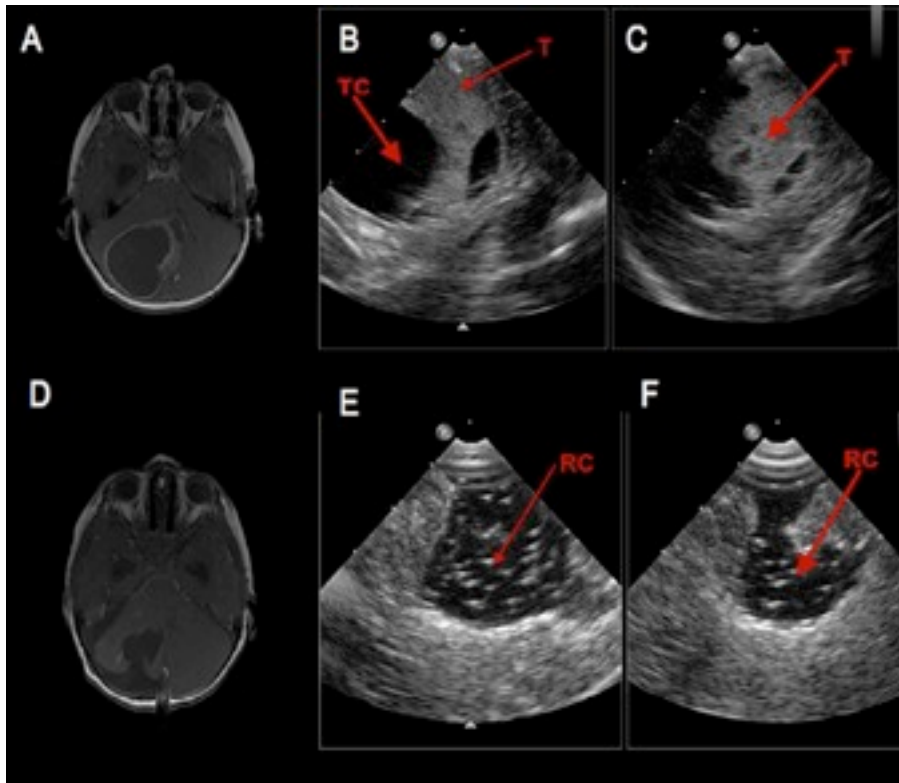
Preoperative axial T1 MRI with contrast (A) of a 4-year old male patient with a pilocytic astrocytoma in the right cerebellum and the corresponding intra-operative rt-3D IOUS images (B, C) in “X- Plane” mode as shown in the coronar (B) and sagittal (C) planes before tumor removal. Rt-3D IOUS of the coronar (E) and sagittal (F) planes and post-operative axial T1 MRI with contrast after 24 hours (D) confirm total removal of the lesion. TC Tumor cyst, T Tumor, RC Resection cavity
